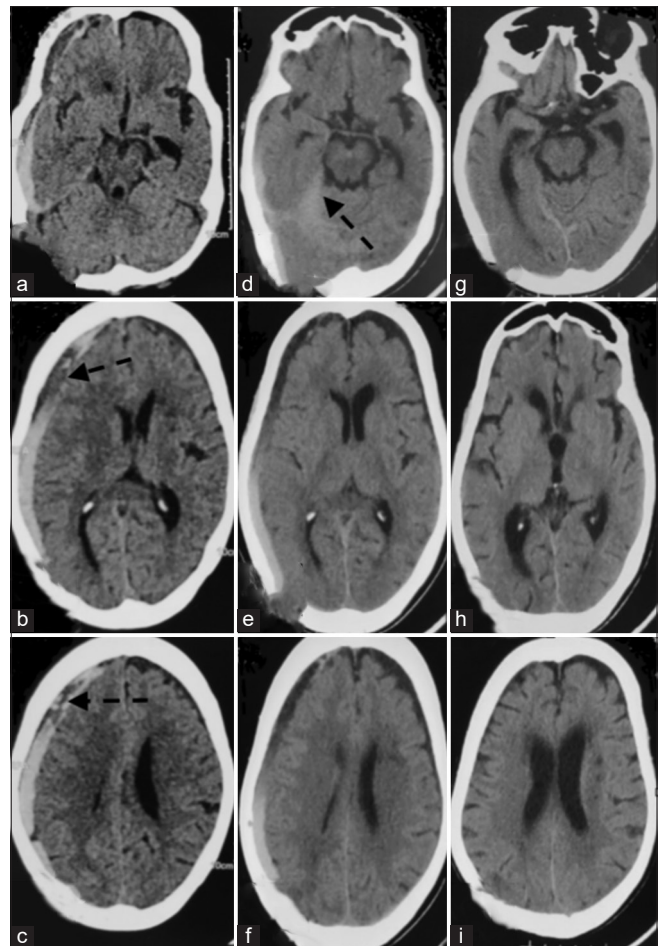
(a-c) (1 h after trauma) computed tomography scan showing 10 mm thick acute subdural hematoma with 7.3 mm midline shift and mixed density clot in frontal portion of subdural hematoma (marked with broken arrow). (d-f) (7 h after trauma) computed tomography scan showing marked resolution of acute subdural hematoma to 5 mm thickness and midline shift of 3 mm. Some redistribution of clot seen along the tentorium cerebelli (marked with broken arrow) (d). (g-i) (4th day of trauma) computed tomography scan showing complete resolution of clot with no midline shift
